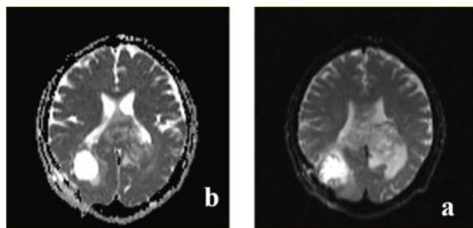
Example of DWI (a) and ADC (b) images of a patient with glioma
